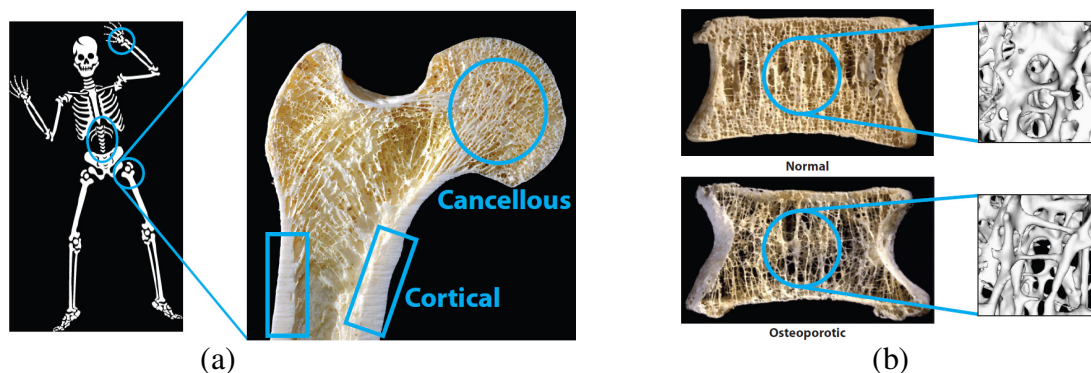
Locations within the human skeleton at greatest risk for osteoporotic fracture. (a) The wrist, spine, and hip (at left, in circles) are the most common sites of osteoporotic fracture. These sites contain a large amount of cancellous bone, which is porous bone (at center, in circle), while cortical bone (at center, in squares) is dense, compact bone. (b) Cross-sectional images (at right) from a normal (top) and an osteoporotic (bottom) vertebra [4], with associated representative micro-computed tomography scans (at right).
